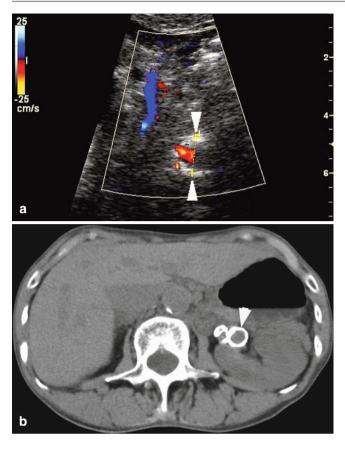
(a) A left renal artery aneurysm is measured transversely on a sonographic image. Color flow evaluation is difficult due to circumferential calcification in the wall of the aneurysm. (b) The calcified aneurysm, located just beyond the bifurcation of the renal artery, is seen on CT scan without intravenous contrast
